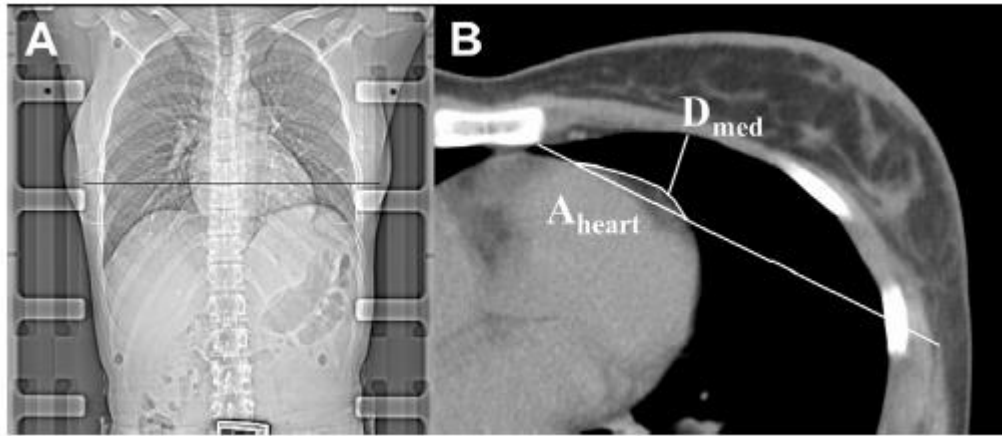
The simple clinical tool generates patient-specific data to predict the benefit of prone positioning. After selecting the reference plane (P_{ref}) at the middle of the heart on the AP scout view (A), a single CT slice is acquired for the measurement of those determinants (D_{med} and A_{heart}) (B) which operate the calculator to provide estimates of the doses to the LAD or heart.
